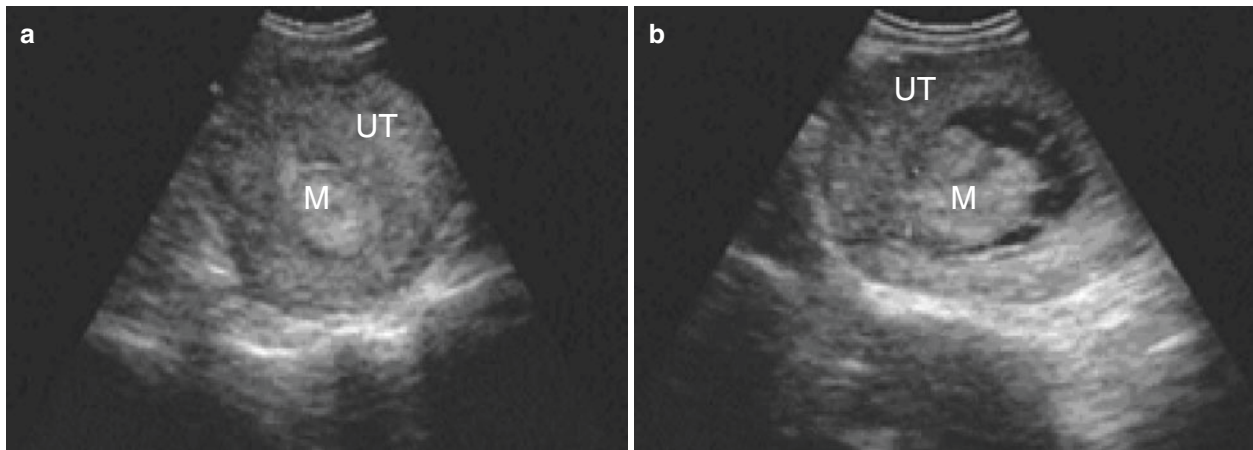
Sonohysterography of single endometrial polyp (III) (a). A 29-year-old patient has a hyperechoic mass with a diameter of 2.0 cm in the uterus by vaginal ultrasonography. (b). After injection of contrast
